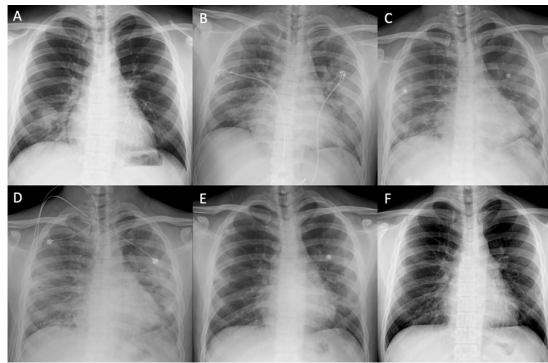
(A) Chest x-ray on admission, day 1, demonstrated patchy alveolar infiltration in the right lower lobe. (B) Day 7, progression to bilateral peripheral consolidation predominated more on left sided. (C) Day 10, infiltration improved after tocilizumab. (D) Day 14, infiltration once again progressed to bilateral peripheral consolidation. (E) Day 18, two days after pulse methylprednisolone, infiltration improved. (F) Chest X-ray on 2 weeks follow-up was much improved. Only minimal peripheral ground glass was observed.
